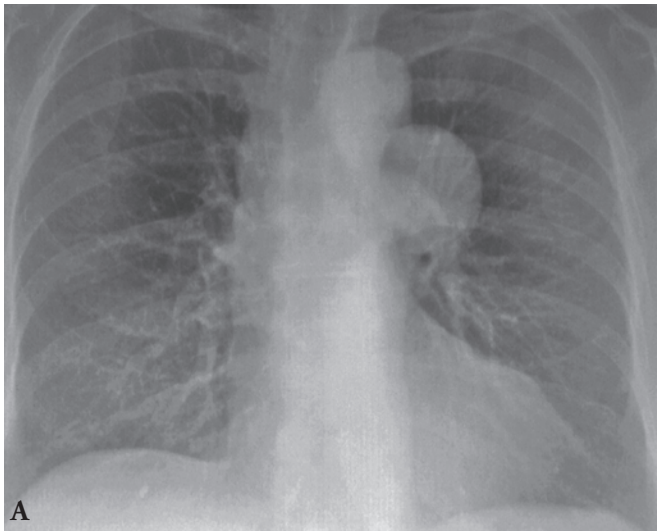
A* and *B*, Chest radiographs (*A*, anteroposterior; *B*, lateral) show a large mass in the left posterior chest. *C*, Computed tomogram shows a saccular aneurysm in the mid-descending thoracic aorta.
